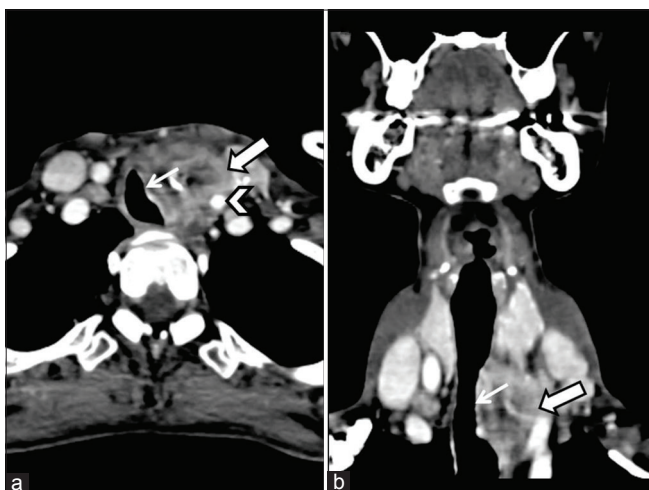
(a and b) Contrast-enhanced computed tomography of the neck showed an enlarged thyroid gland with multiple nodules. The largest nodule in the left lower pole (white arrow) showed heterogeneous enhancement with foci of coarse calcification and mass effect to the adjacent trachea (thin white arrow), causing narrowing of its lumen. There was encasement of the left common carotid artery (arrowhead) by this mass
